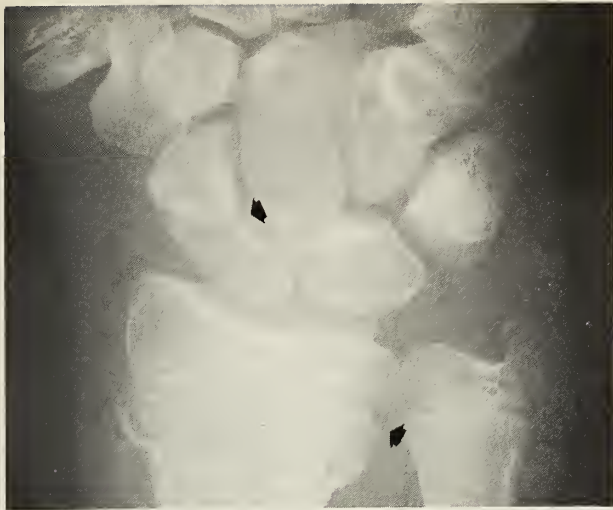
Radiograph showing a non-displaced fracture through the waist of the scaphoid and a distal radius fracture. The scaphoid fracture was missed in this child.
